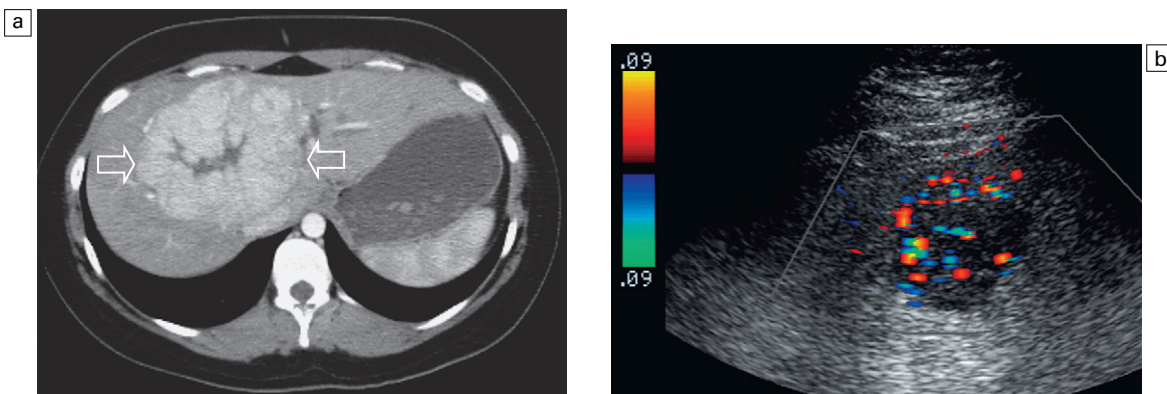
(a) Arterial phase of a contrast enhanced CT scan through the upper liver. A briskly enhancing round mass with a central scar is clearly evident (arrows). (b) Colour Doppler through the lesion shows it should be hypervascular. Biopsy confirmed this lesion to be focal nodular hyperplasia.
